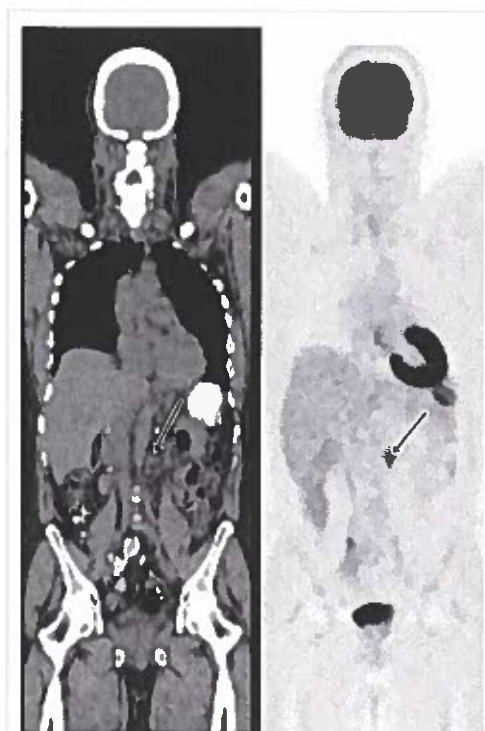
Demonstration of metastatic lymph node on FDG PET/CT.
